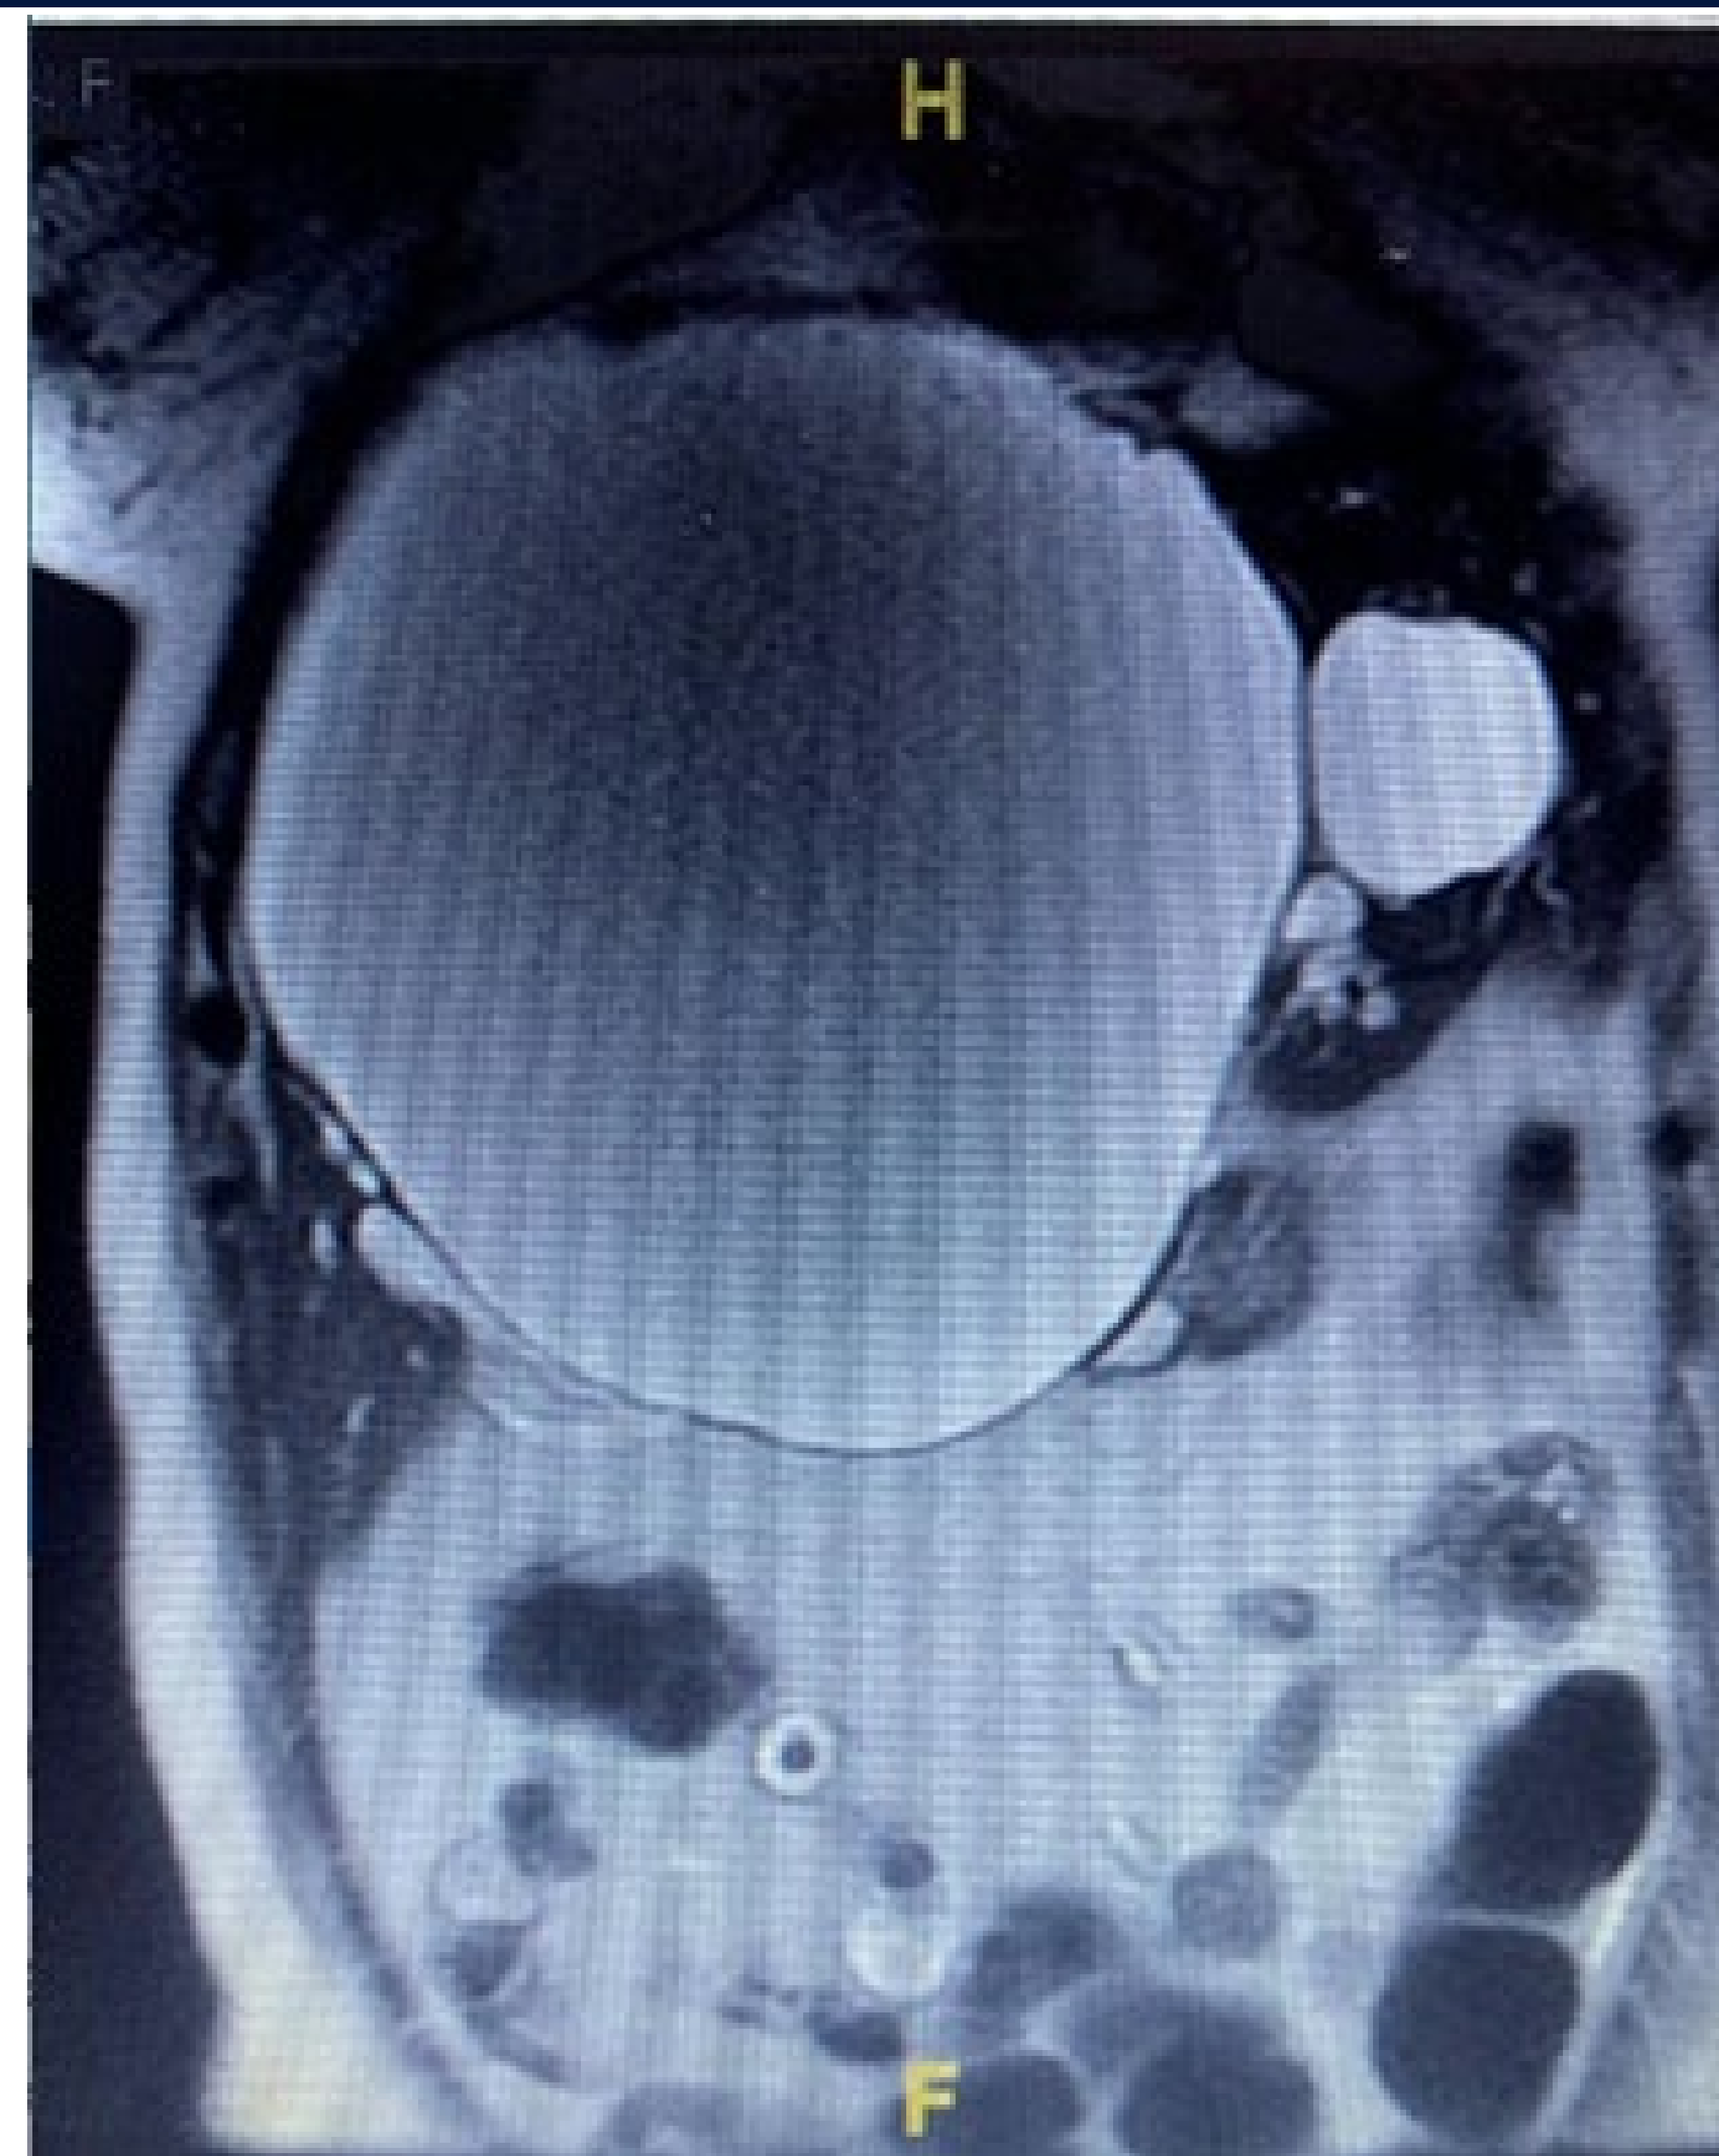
Abdominal MRI with and without contrast: Multiple hepatic simple cysts, largest being 21 x14 x 20 cm, which compressed the central biliary system and resulted in significant intrahepatic biliary ductal dilation though normal common bile duct caliber
